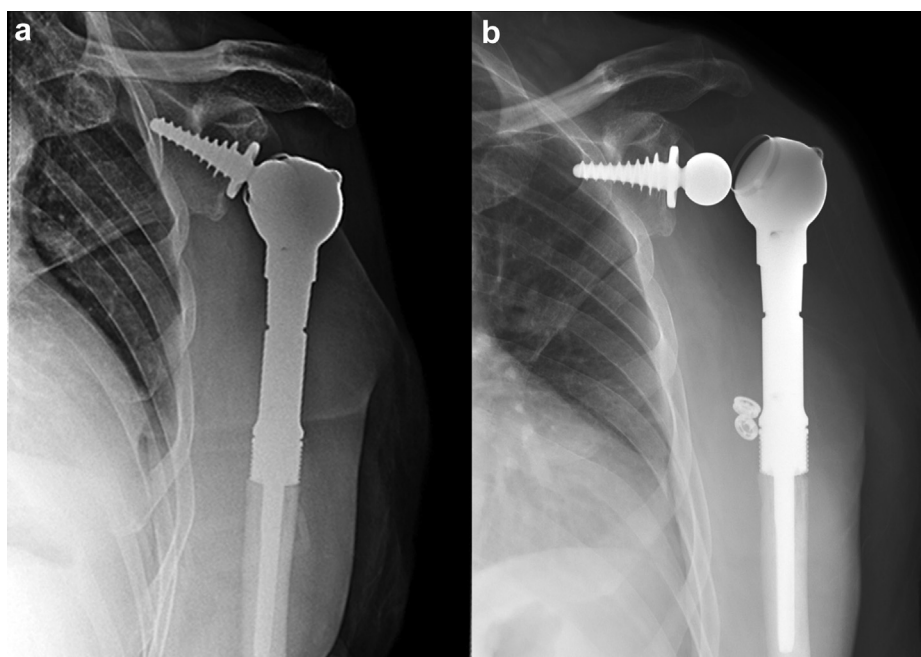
(a) Radiograph in a 70-year-old male patient who underwent placement of a constrained reverse Bayley-Walker prosthesis for chondrosarcoma resection. (b) Radiograph of the same patient showing dislocation of the Bayley-Walker prosthesis with the locking ring intact at 5 months postoperatively.
